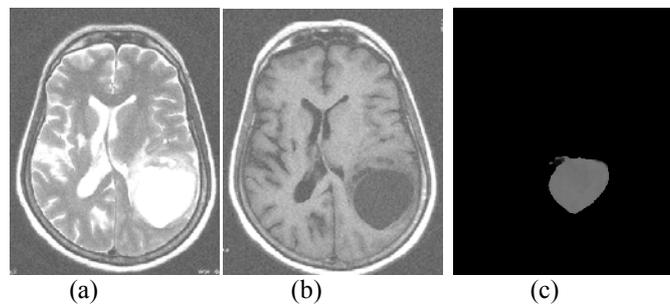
shows the example for checking performance of AGASA on Gaussian noise added images of 20dB SNR. (a) T2- weighted (b) T1-FLAIR (c) segmented tumor
